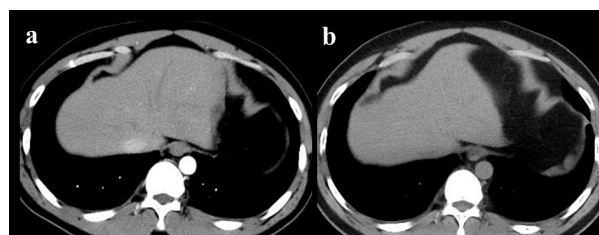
Postoperative abdominal CT scans showing that the left lateral segment of the liver was absent in the case 2. (a) Abdominal CECT in the first postoperative month. (b) Abdominal unenhanced CT scan in the 6th postoperative month.
